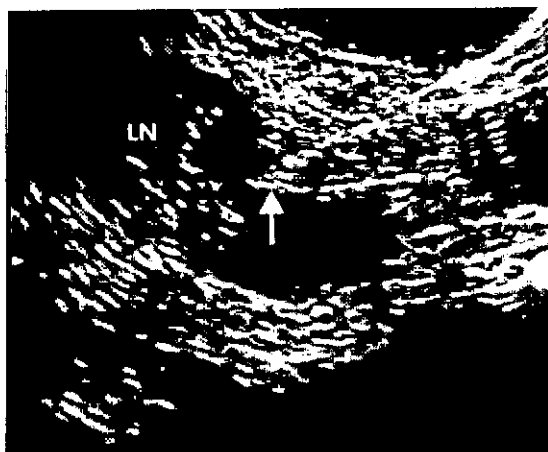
Endosonographic puncture of a large lymph node (LN) in the mediastinum; the needle tip is marked by an arrow.
